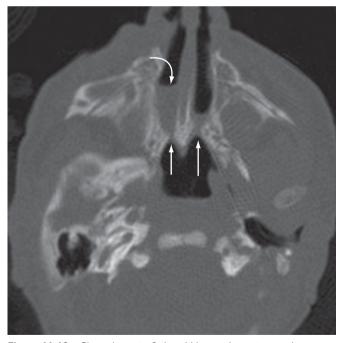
Choanal atresia: 2-day-old boy with respiratory distress. CT image demonstrates marked narrowing of the bilateral choanae (*arrows*) with air-fluid levels in the nasal cavities (*curved arrow*) consistent with mixed bony and membranous choanal atresia.
